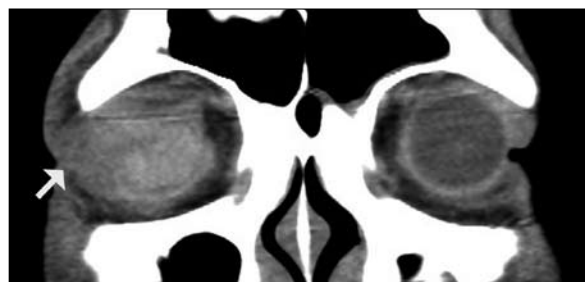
Computed tomography of the orbit showing a distorted right globe (arrow) with the 'flat tire' sign compatible with a ruptured eyeball
